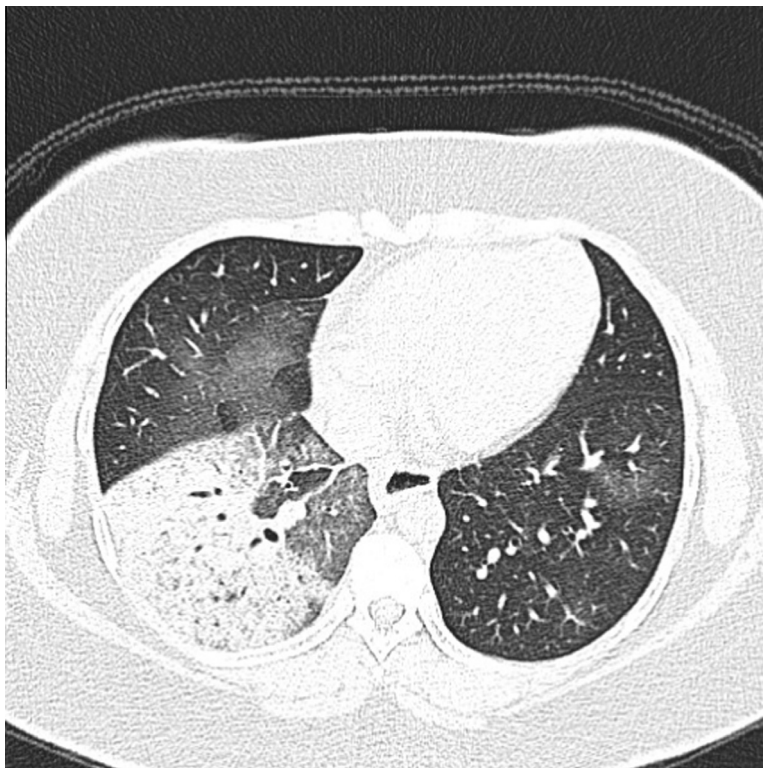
Axial CT scan in lung window setting showing dense consolidation within the right lower lobe with bilateral patches of ground glass opacities.
